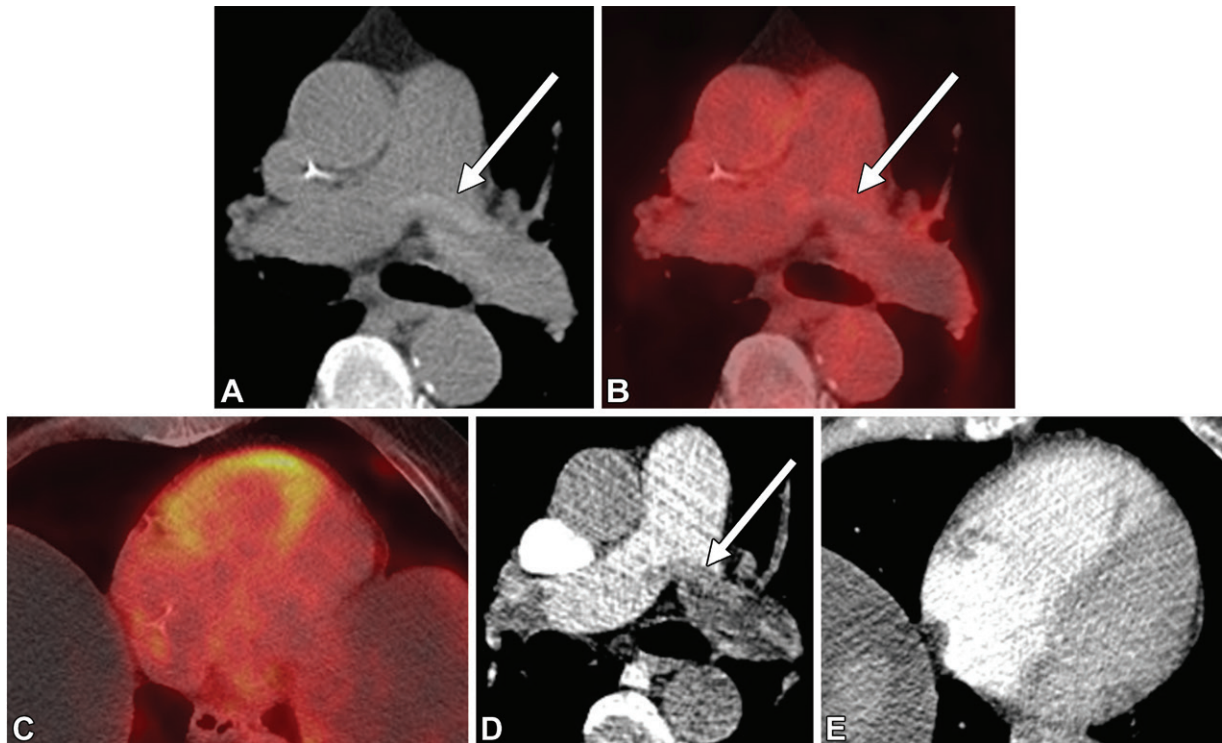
Hyperattenuating lumen sign, indicative of PE, in a 72-year-old man who presented for FDG PET/CT evaluation owing to suspected recurrence of pancreatic cancer. (A, B) Transaxial noncontrast CT (A) and fused FDG PET/CT (B) images show an incidentally noted hyperattenuating lumen sign (arrow) at the pulmonary artery bifurcation and left pulmonary artery without FDG avidity. (C) Transaxial fused FDG PET/CT image shows increased RV uptake, suggestive of RV strain. (D, E) Findings on subsequent contrast-enhanced transaxial CT images confirm the presence of central PE (arrow in D), with RV dilatation and a flattened interventricular septum, suggestive of RV strain (E).
